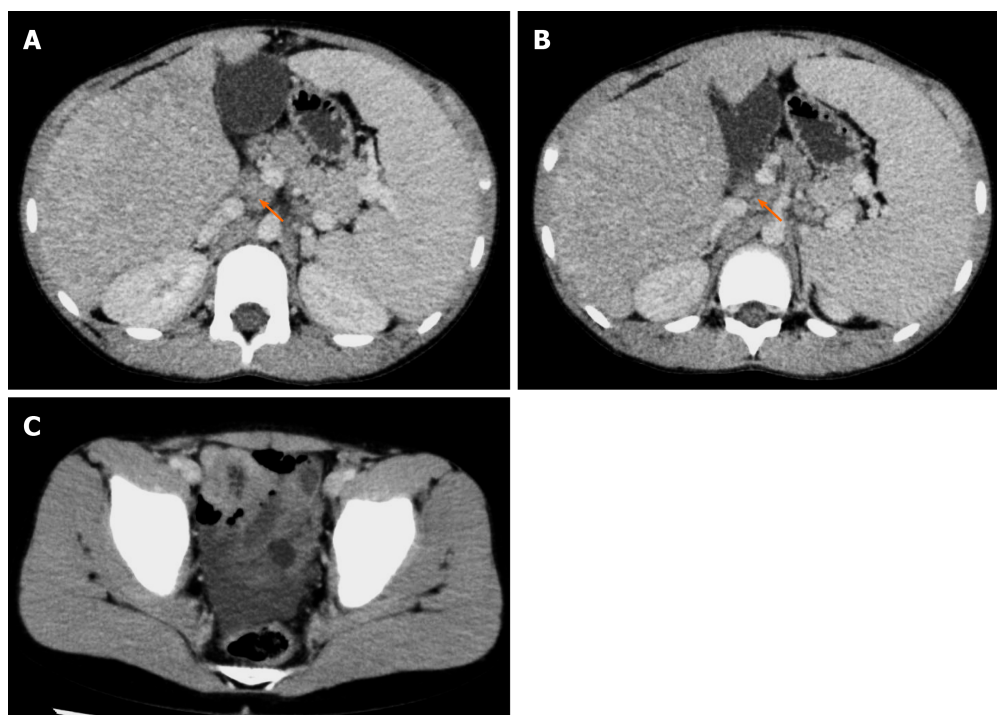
Abdominal contrast computed tomography. A and B: Arrow represents hepatic lymphadenopathy; C: A small number of ascites was observed.
